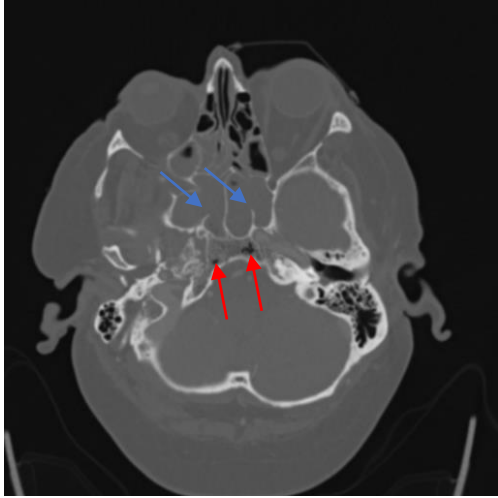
Head CTA Axial section demonstrates sinusitis (blue arrows) and gas within the clivus (red arrows)
